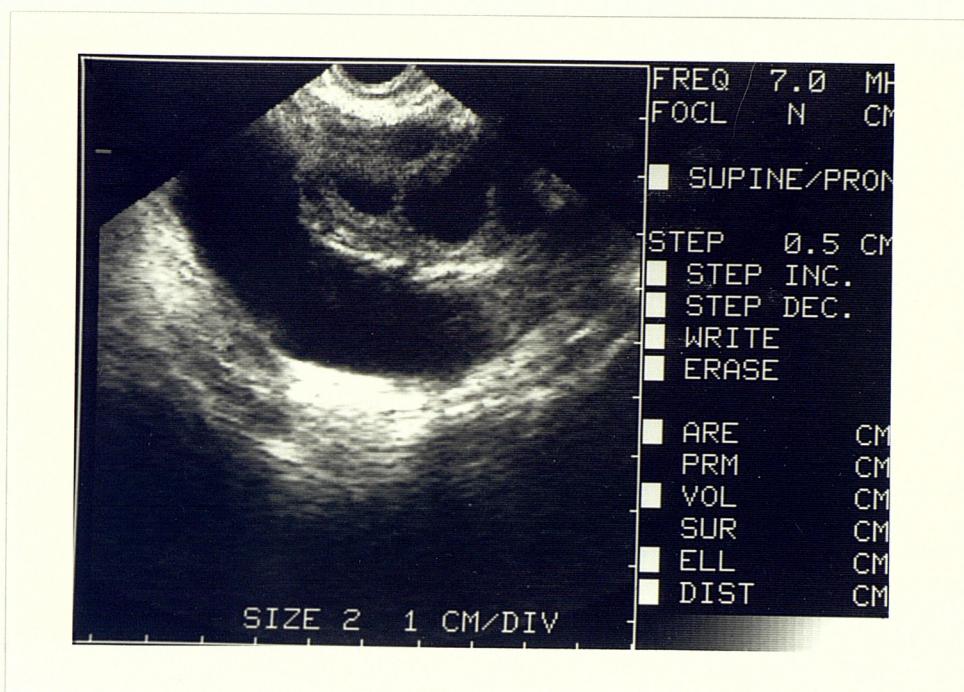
Transvaginal ultrasound of hydrosalpinx
